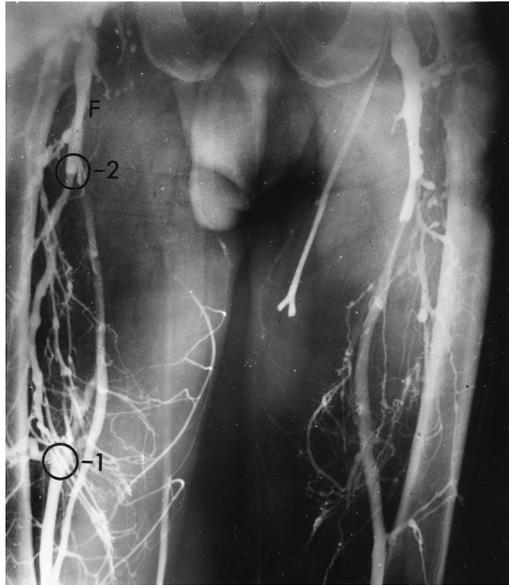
Postmortem venogram of the thighs. There is definite radiographic evidence of occlusion of the femoral vein between points 1 and 2. There is no filling of the femoral vein (F) between these points. Dilated and tortuous collaterals pass around the site of occlusion. No thrombus was found on dissection of the veins of the thigh of this patient, presumably because dissection was carried out along the collateral vessels in this area rather than the femoral vein. (This apparent femoral vein occlusion was not included among the positive cases reported in Stein and Evans [35].)
